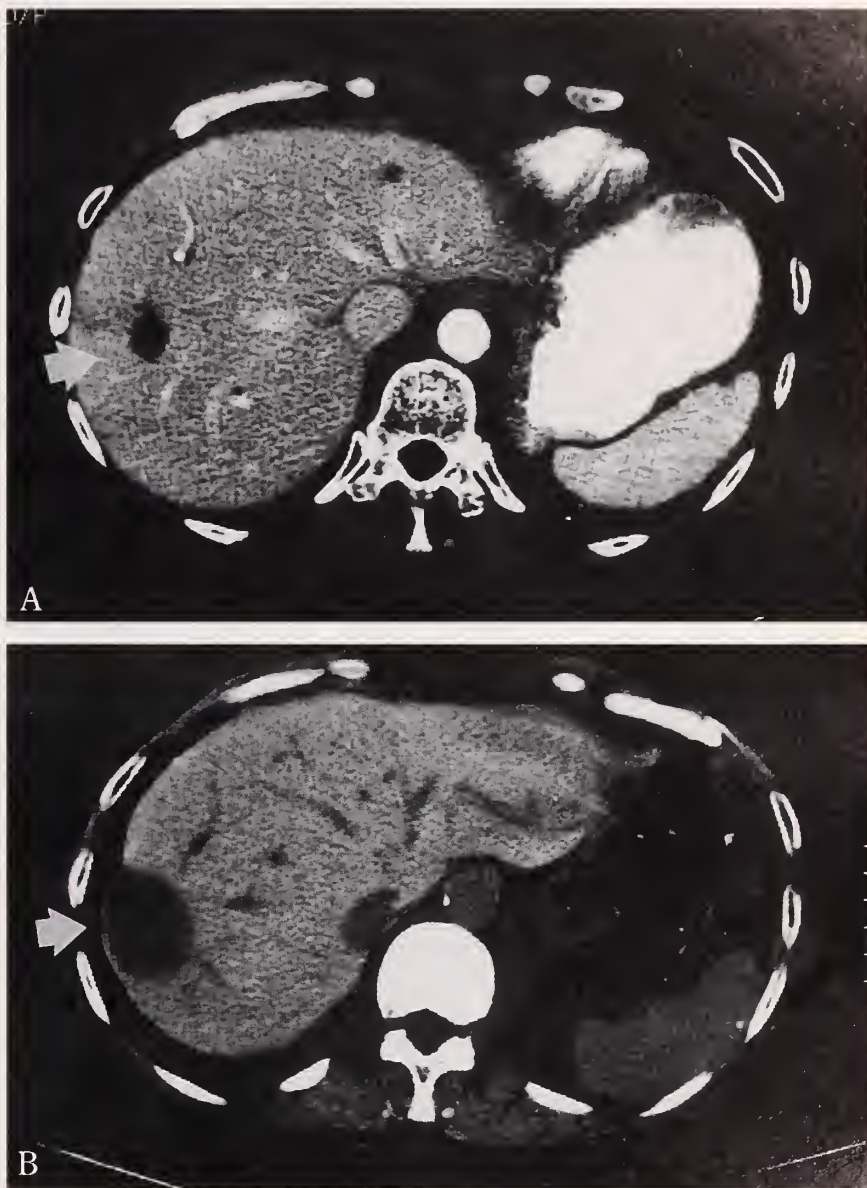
A, preoperative CT angiogram of the patient shown in Fig 3. A metastasis is present in the right lobe of the liver (arrow). The small lesion shown in the left lobe of the liver was a cyst. B, CT scan 6 months postoperatively shows the cryoablated site (arrow).
